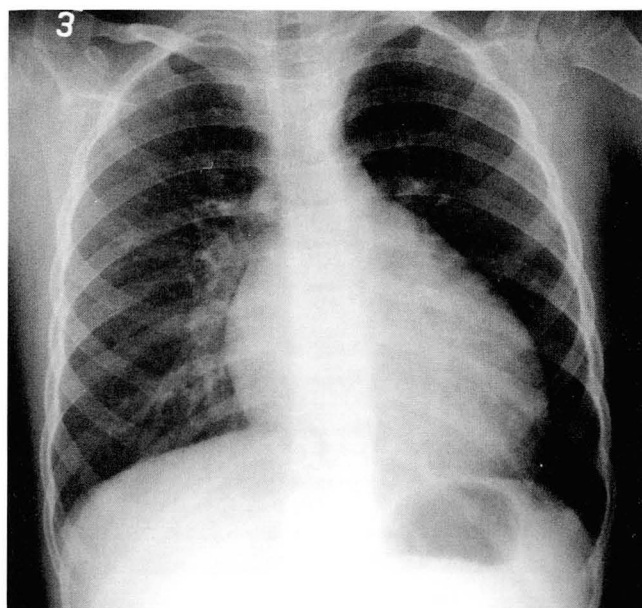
Adriamycin-induced dilated cardiomyopathy. A 4 year-old girl with acute myeloid leukemia was treated with daunomycin and cytarabine. Plain chest radiograph shows moderate to severe cardiomegaly which is consistent with dilated cardiomyopathy.
